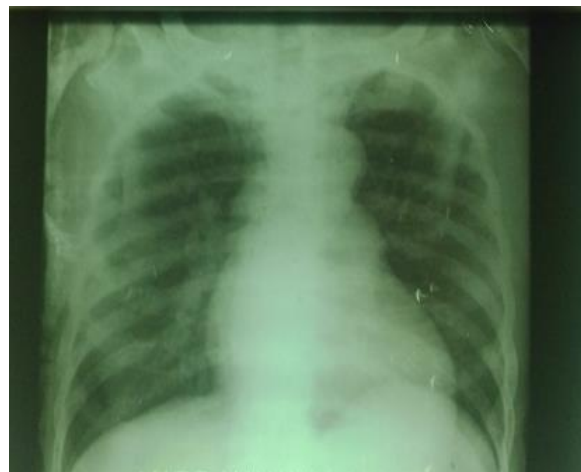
Plain radiograph of the chest in anterior-posterior projection demonstrating mild cardiac enlargement with aortic unfolding, hyperinflation of the lung fields most likely from emphysema with diffuse osteosclerosis of the thoracic cage and spine.
